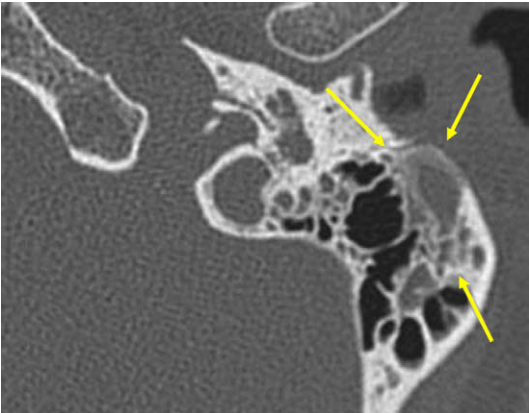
Axial CT image acquired from a patient experiencing otalgia. Note the opacification of air cells and the partial obliteration of air cells by new bone formation (*area surrounded by arrows*). New bone formation strongly suggests persistent inflammation (periostitis).
